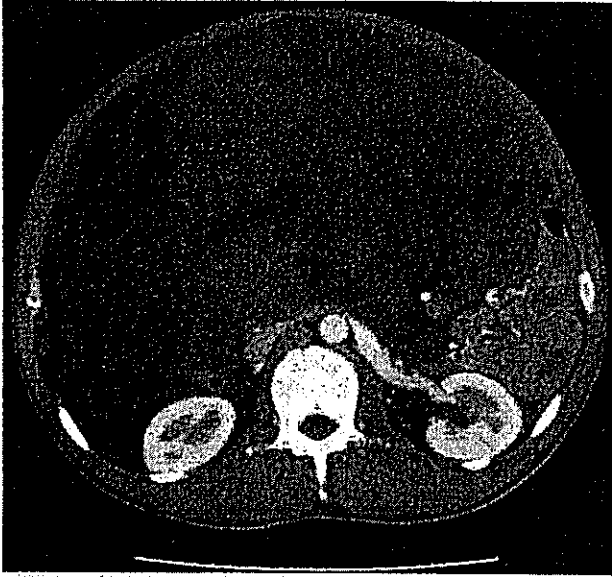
Pre-operative enhanced computed tomography. The peritoneal cavity was almost totally occupied by the huge tumor and an extremely distended abdomen was found.
